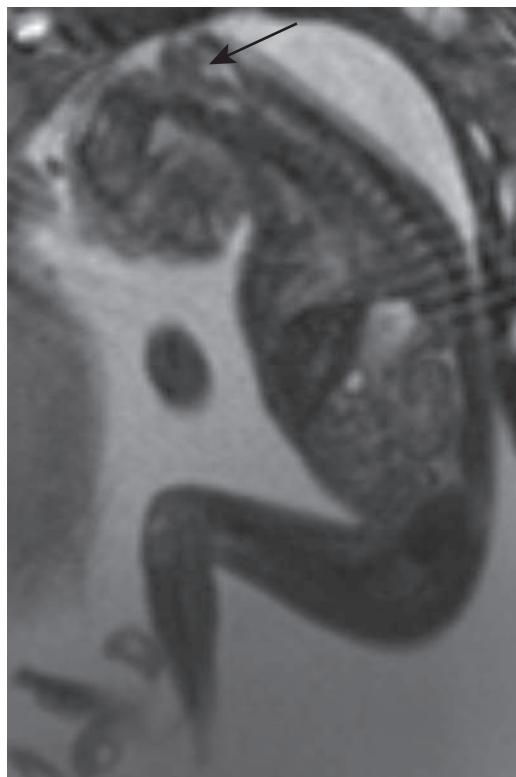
Anencephaly. On this sagittal MR image of an 18-wk-gestational-age fetus, there is abrupt truncation of the neuraxis above the brainstem (arrow), no cerebral tissue, and an open skull defect exposed to amniotic fluid consistent with anencephaly.
